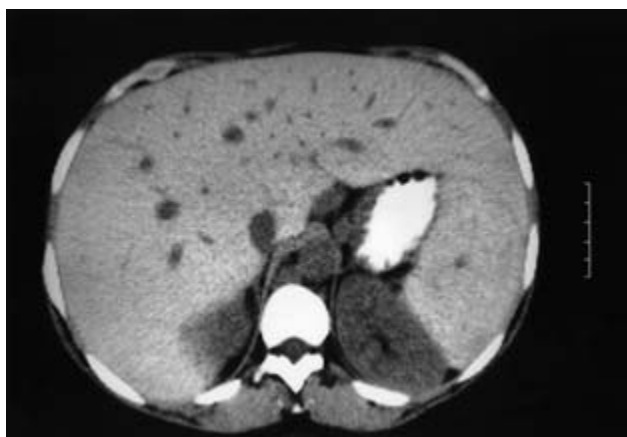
Unenhanced CT scan of secondary iron overload in thalassaemia major. The liver shows increased density, greater than that of the kidney. Portal vein radicles are very prominent.
